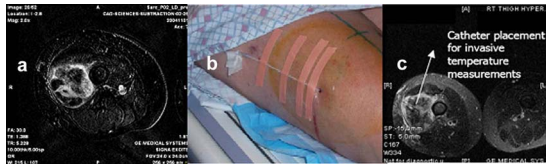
(a) DCE-MRI subtraction image between the baseline and the maximum intensity scan (60 s postcontrast agent injection) used to guide the catheter placement to acquire data from three physiologically diverse areas: Normal tissue, viable tumor, and necrotic tumor (if any). (b) Image showing catheter placement in one of the patients with a right thigh high grade STS. (c) Postcatheter insertion MR verification, showing the catheter spanning the three areas to be monitored: Normal tissue, viable tumor, and necrotic core.
